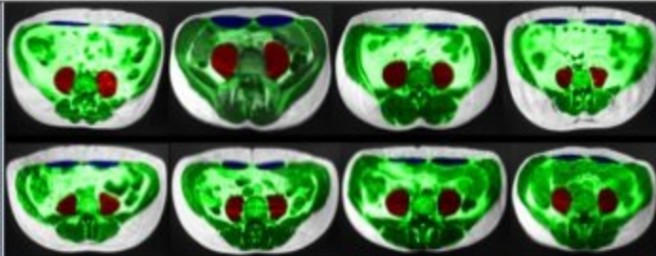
Magnetic resonance imaging of the trunk area obtained at L5. Psoas(red), rectus abdominis(blue) and total trunk CSA(green) were calculated.
